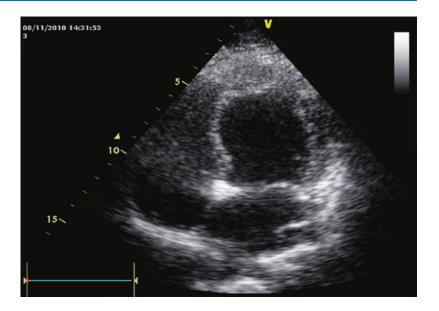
Apical four chamber: female patient with amyloidosis; note the reducted dimension and volume of left ventricle
